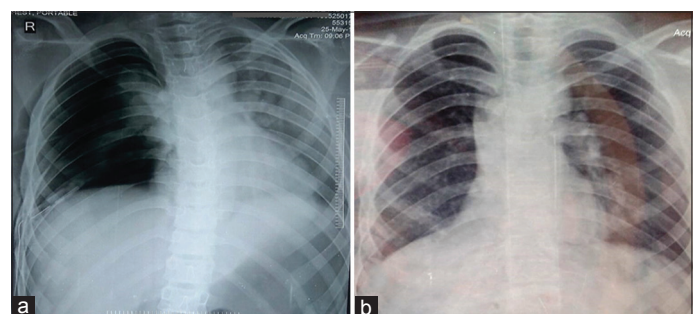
(a) Immediate post-operative X-ray and (b) follow-up X-ray after 4 months
